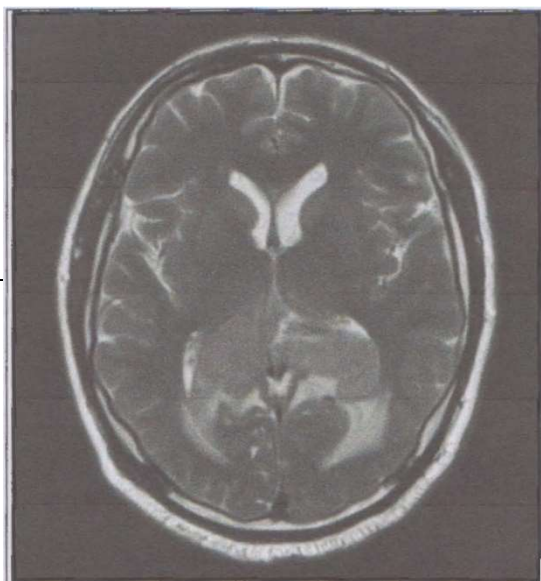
T2W MRI brain with contrast
